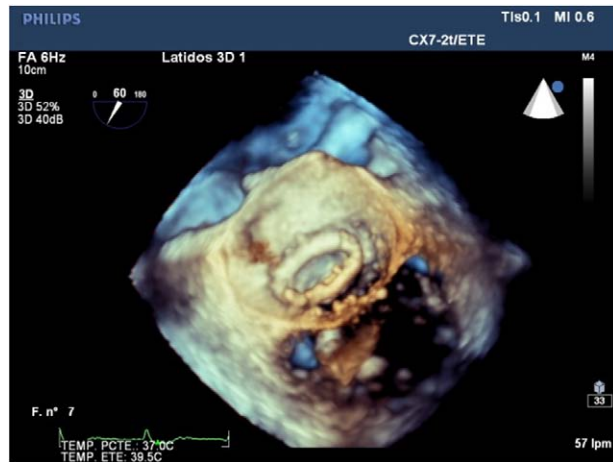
Three-dimensional transesophageal echocardiography: mitral ring dehiscence.
